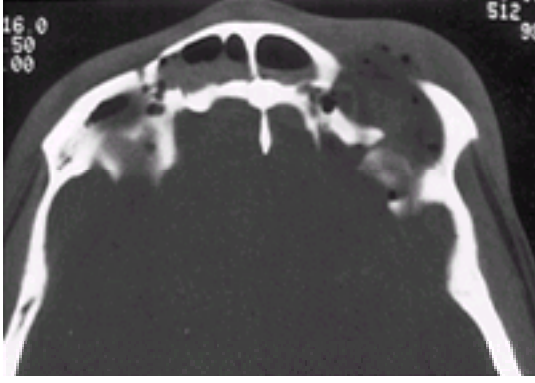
Axial computed tomography (CT) scan on the upper face in a patient with forehead lacerations. A bony defect in the anterior wall of the frontal sinus and fracture of the posterior wall on the patient's left side (*right side* of photography) suggest a fracture through both walls of the frontal sinus. Note the air–fluid levels in both sides of the sinus. Before CT, such detailed information regarding the status of the posterior wall was unavailable without operative examination.
